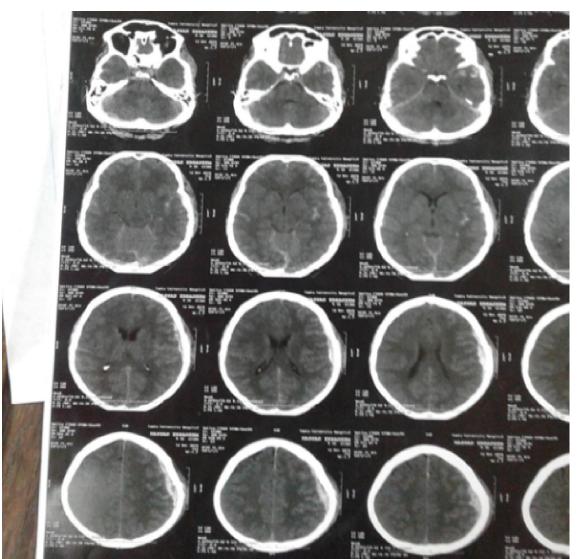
CT brain of case 1 after 48 hrs.
